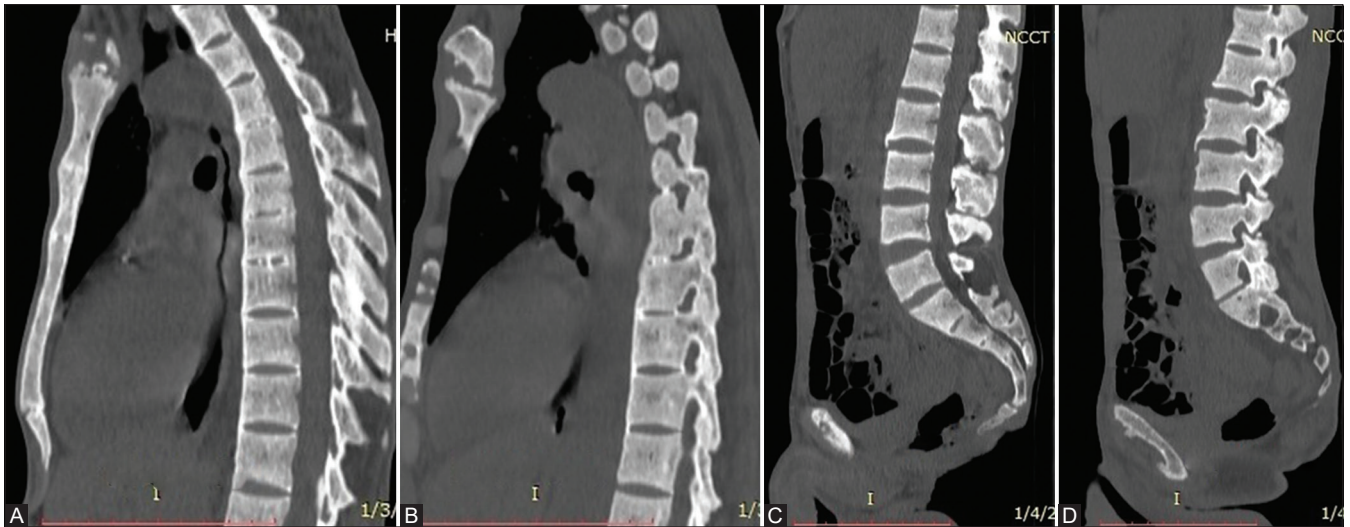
(A-D): (A-D) Midsagittal and parasagittal reformatted CT images of thoracic (A and B) and lumbar spine (C and D) showing diffuse osteosclerosis and facet joint arthropathy. Ossification of an anterior longitudinal ligament in the thoracic spine along with the varying degree of disc calcification. Syndesmophytes also noted in the lumbar spine
